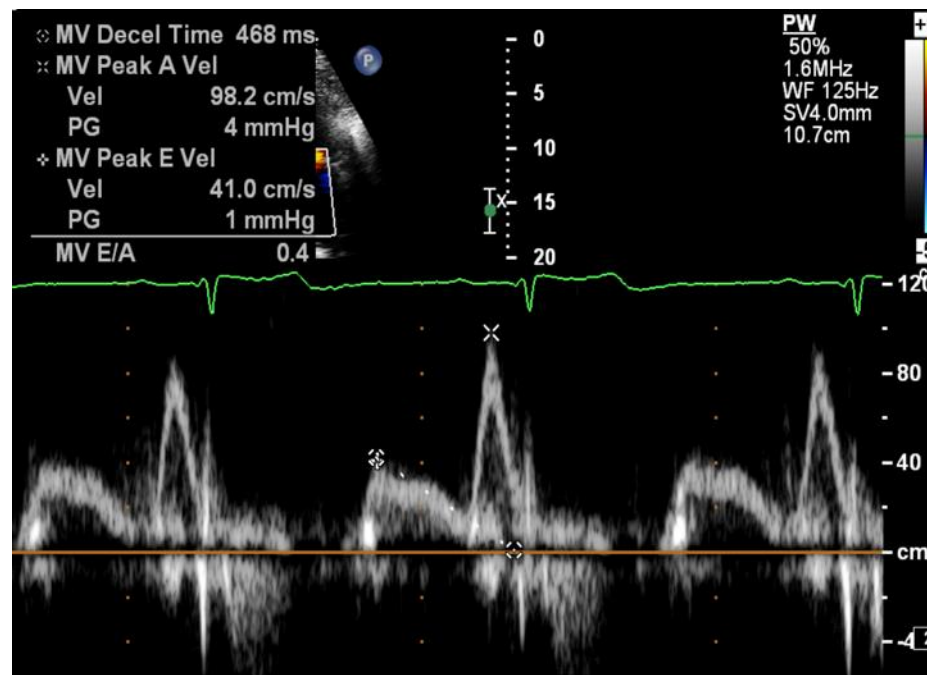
Pulsed-Wave (PW) doppler at the tips of the mitral valve showing the E-wave, A-wave, E/A ratio and the deceleration time.
